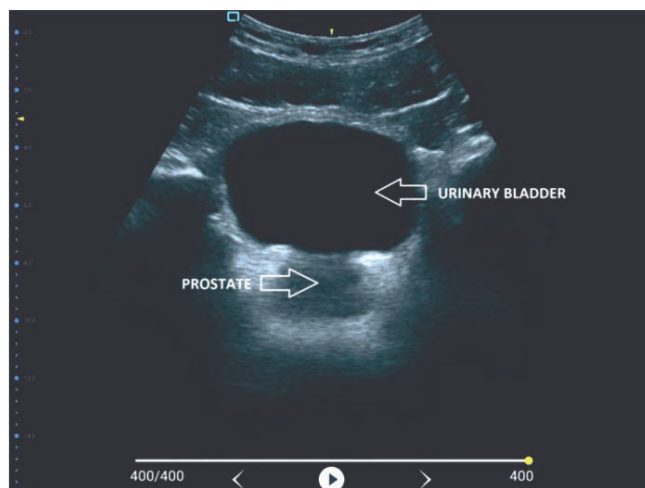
Pelvic ultrasound image from the transverse position
